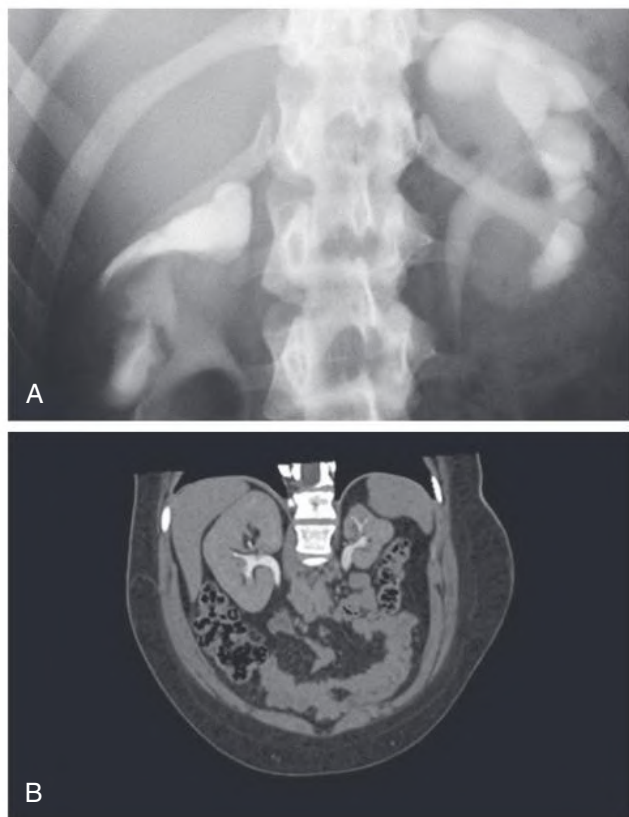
Kidney Dysplasia. (A) Intravenous urogram (IVU) shows gross bilateral scarring in a 20-year-old woman who has been followed since the age of 2 years. Progressive scarring has been observed in the absence of urinary tract infections and obstruction. This probably represents primary kidney dysplasia. (B) Computed tomography IVU shows gross scarring of right kidney. (Courtesy Dr. A. Kirkham, University College Hospitals, London.)
